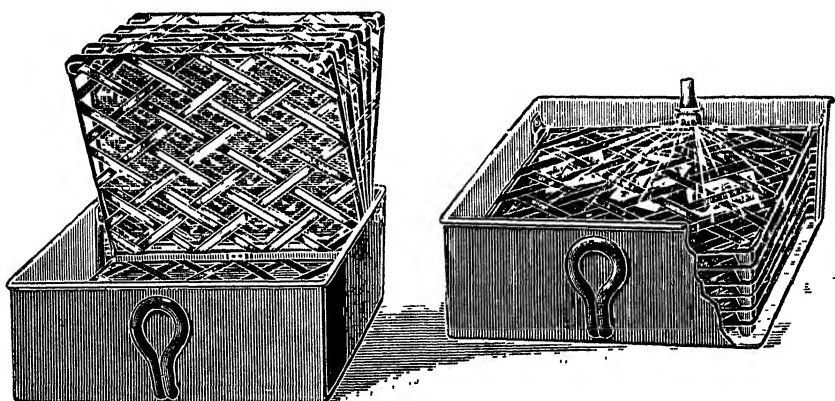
X-RAY PRINT WASHER.
